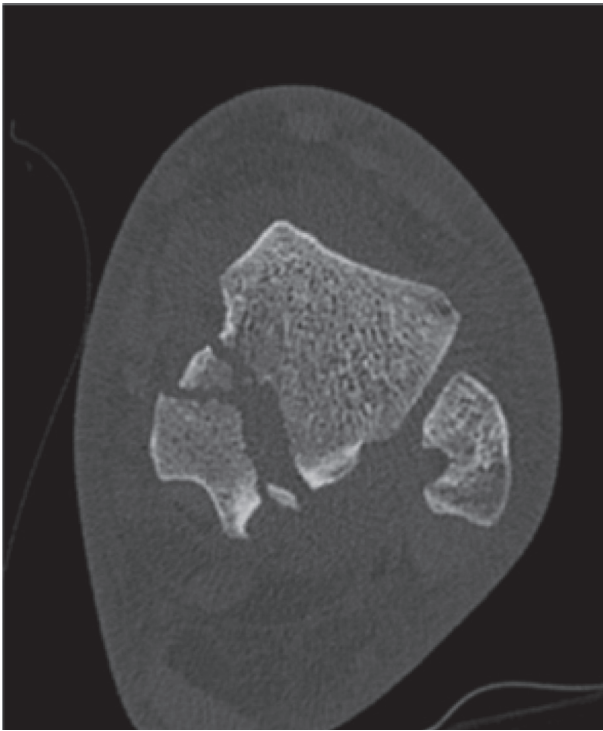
Preliminary CT-scan: axial.
